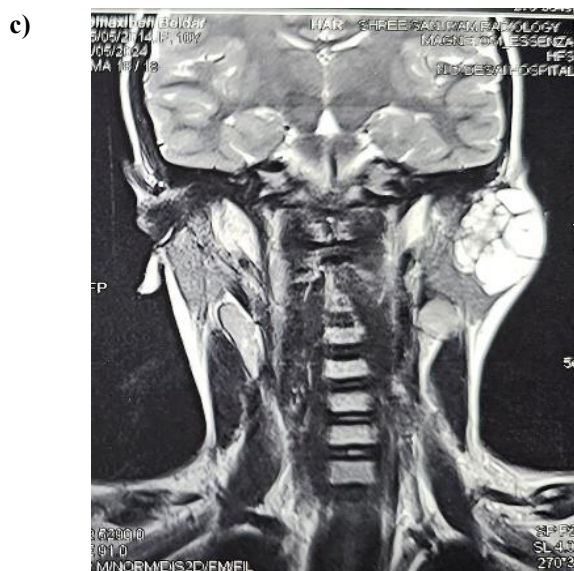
MRI images showing showed 26* 33 * 44mm lesion arising from the superficial lobe of the parotid gland, heterogeneously hyperintense on T2W images. The lesion also extended to adjacent deep lobe of parotid gland and into adjacent subcutaneous plane of the left parotid region p/o Pleomorphic adenoma (T2W a, b axial images, c- coronal section)
